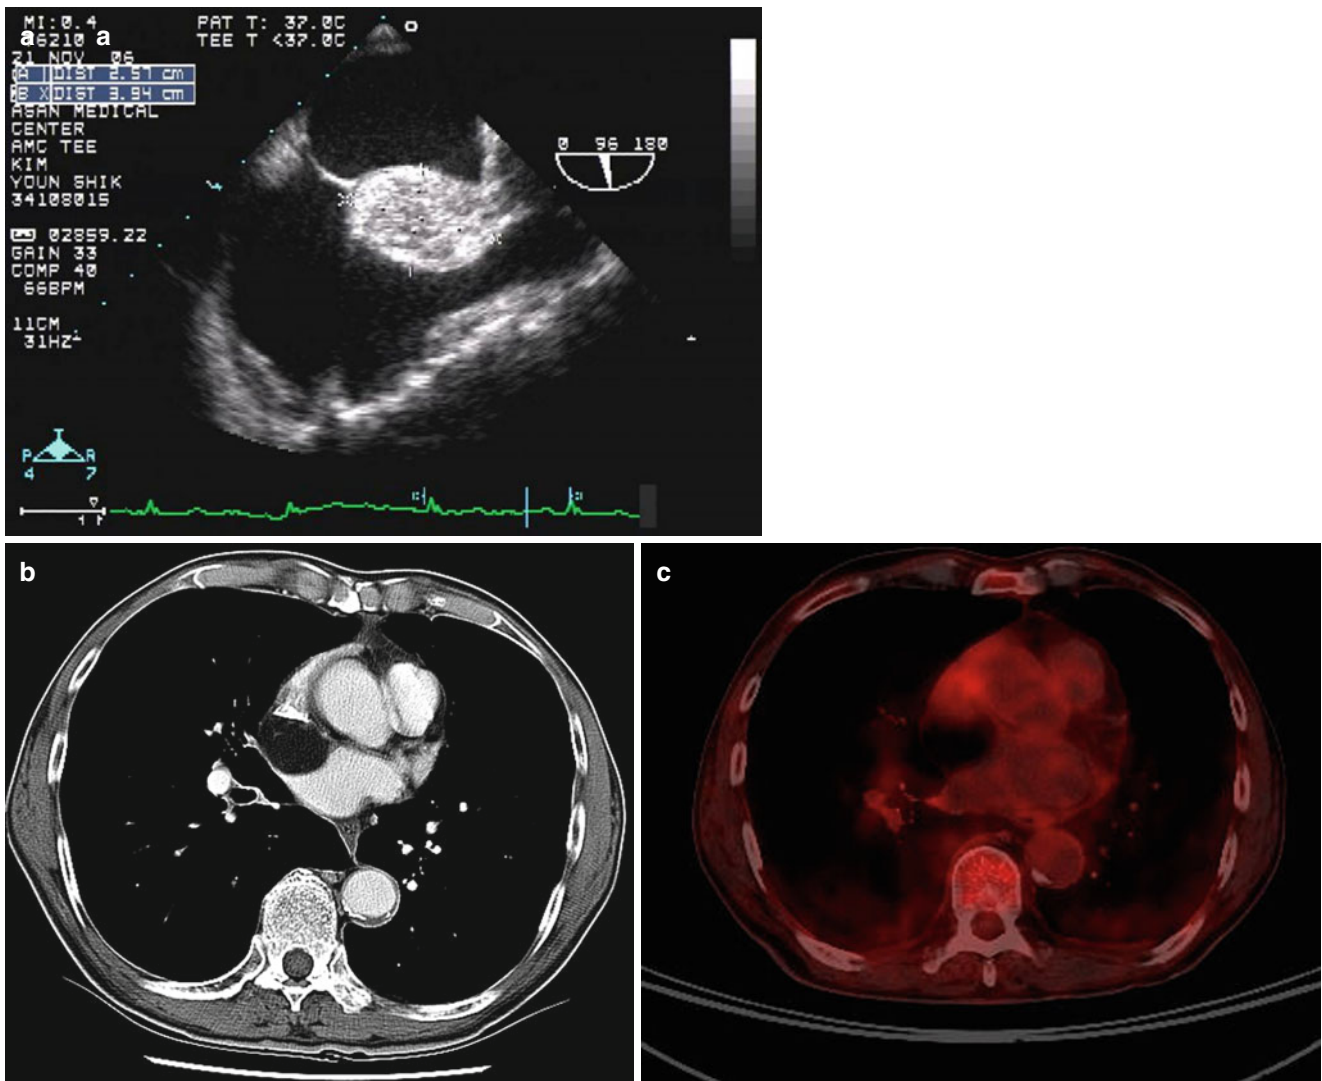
Lipomatous hypertrophy at the interatrial septum. (a) Transesophageal echocardiography shows highly echogenic and ovoid mass located in the interatrial septum. (b) Axial CT image shows
